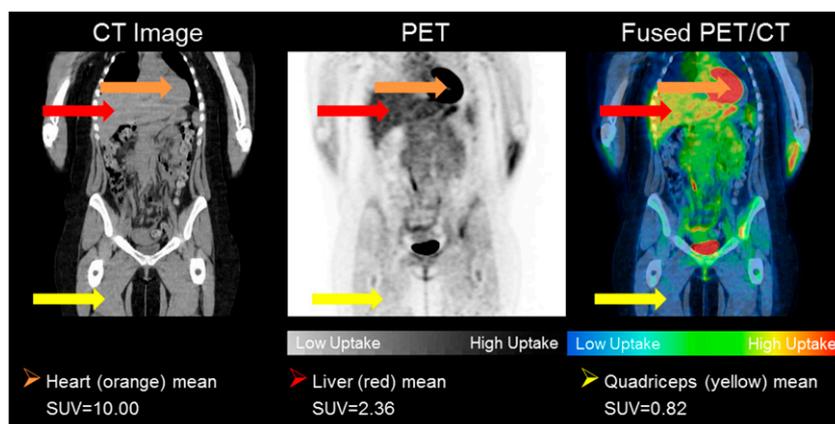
Representative computed tomography (CT), positron emission tomography (PET), and fused PET-CT images of the entire body. Color bars below PET and fused PET-CT image indicate high uptake (black, red) and low/no uptake (white, blue). Heart (orange arrow) has relatively high standardized uptake value (SUV), whereas liver (red arrow) and resting quadriceps muscle (yellow arrow) have significantly lower SUV.
